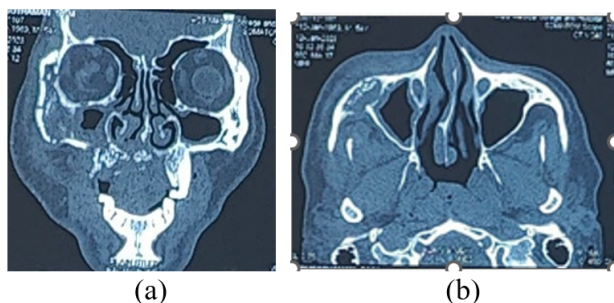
(a, b): CT images showing bony destruction in the right maxillary sinus
